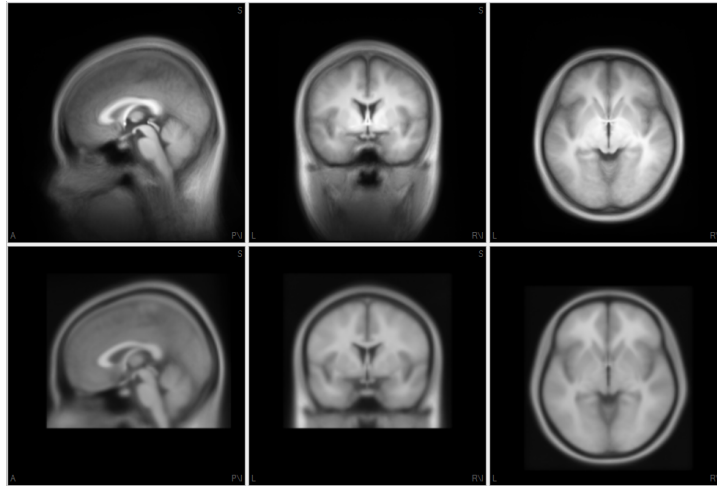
Upper row: MRI-62-A dataset based on 62 Chinese subjects. Lower row: ICBM-152-A dataset with the average Chinese subject's brain dimensions.
